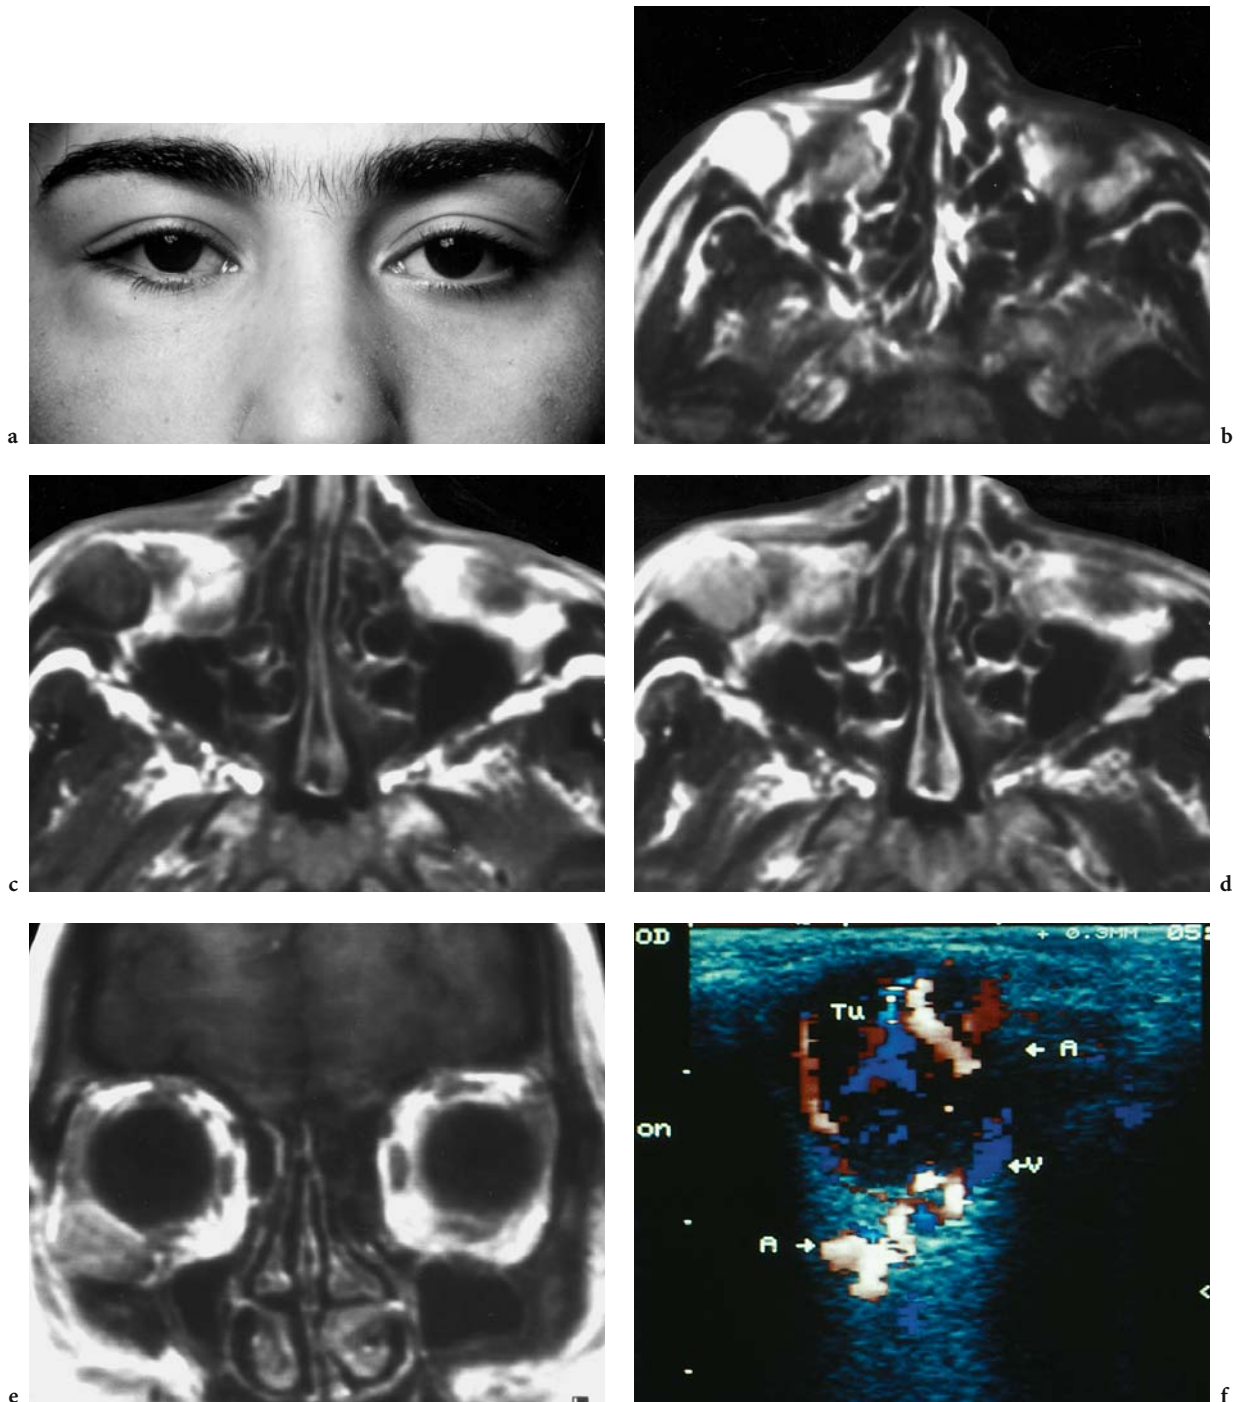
An 18-year-old woman with smooth swelling of the right lower eyelid. Diagnosis: benign hemangiopericytoma. a Portrait, showing the smooth subcutaneous tumor in the inferior lateral region of the right orbit. MRI: b Axial T2-weighted image with a signal-intense, sharply defined mass in the lateral inferior part of the right extraconal space. c Corresponding T1-weighted native image with an intermediate to hypointense signal. d Corresponding T1-weighted, contrast-enhanced image demonstrating distinct, homogeneous signal enhancement of the tumor, extending to the tendon of the inferior rectus muscle. e Coronal, T1-weighted, contrast-enhanced view identifying the inferior rectus muscle to be as small and tender as the contralateral one. f Color-coded Duplex ultrasound with a highly vascularized, sharply defined tumor (*Tu*) and conclusively identified vessel stalk. The macroscopically sharply defined, highly vascularized, noninfiltrating tumor was removed by anterior orbitotomy with confirmation of the sonographically identified vessel stalk (*A* = artery, *V* = vein). (a, f with permission of ROHRBACH and LIEB 1998)
